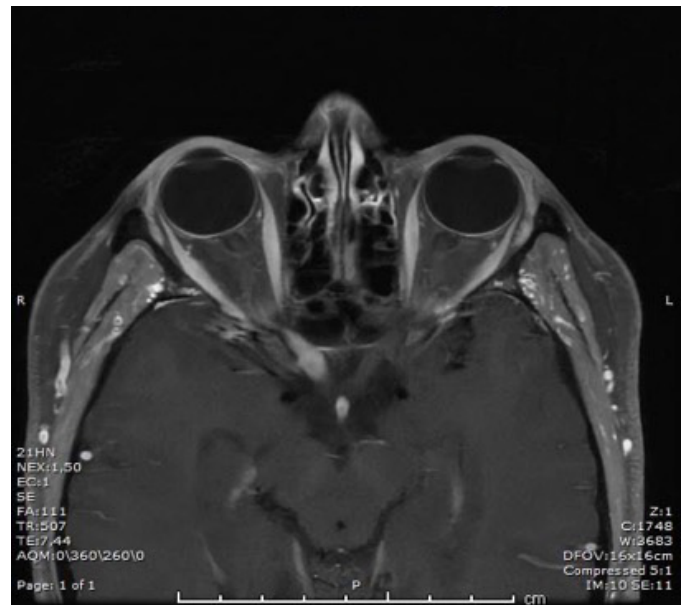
Cranio-orbital MRI stills after treatment
